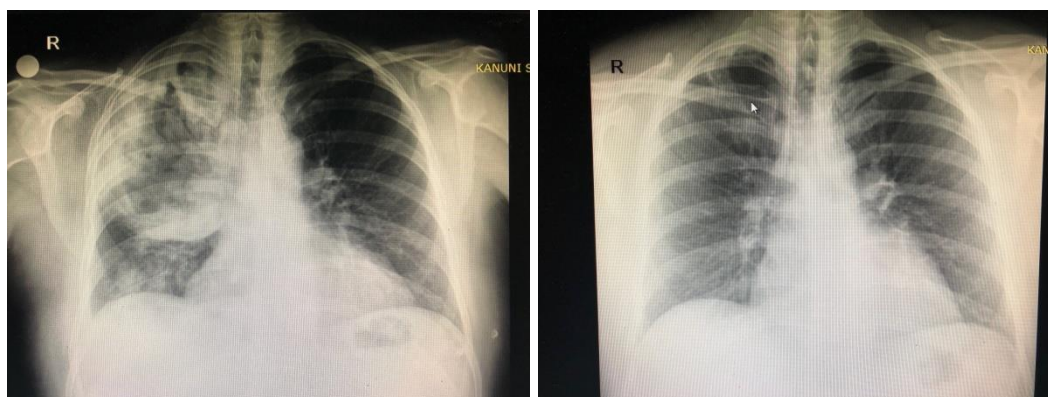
Anteroposterior lung radiography examination of the case at the time of diagnosis and after the treatment (1st month)
